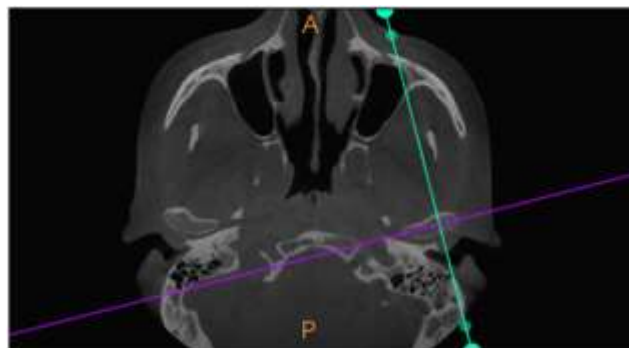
Corrected CBCT image of left condylar region.
